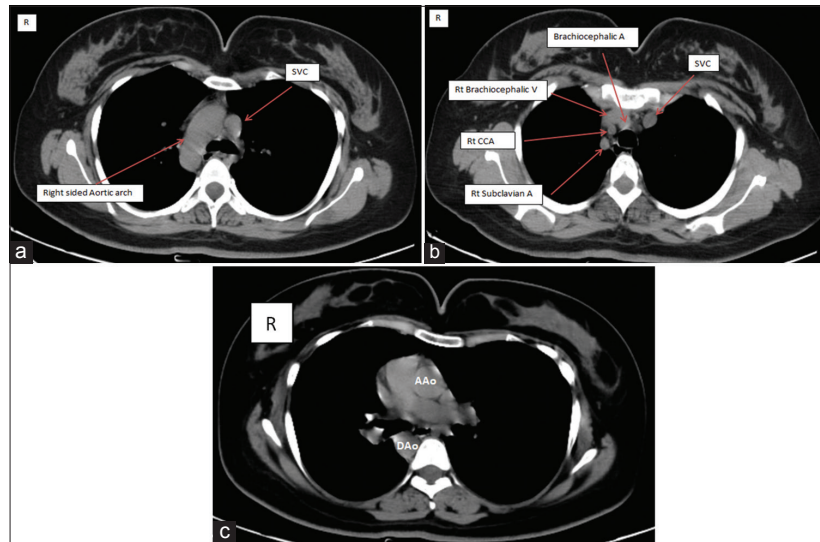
(a-c) Axial computed tomography scan sections at the thoracic and arch of aorta level shows right-sided aortic arch with the left-sided ascending aorta (AAo) and right-sided descending aorta (DAo). Furthermore, complete reversal of origin of great vessels is seen
